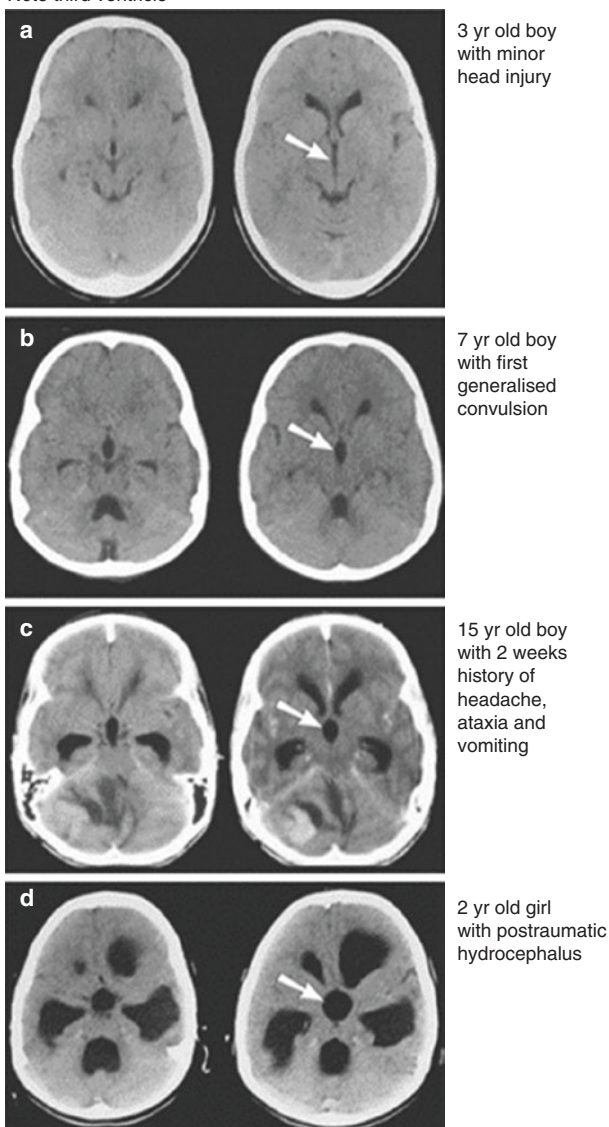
Non-contrast CT scans showing different degrees of hydrocephalus: (a) normal, (b) mild hydrocephalus, (c) moderately severe hydrocephalus, (d) gross hydrocephalus (see text)
